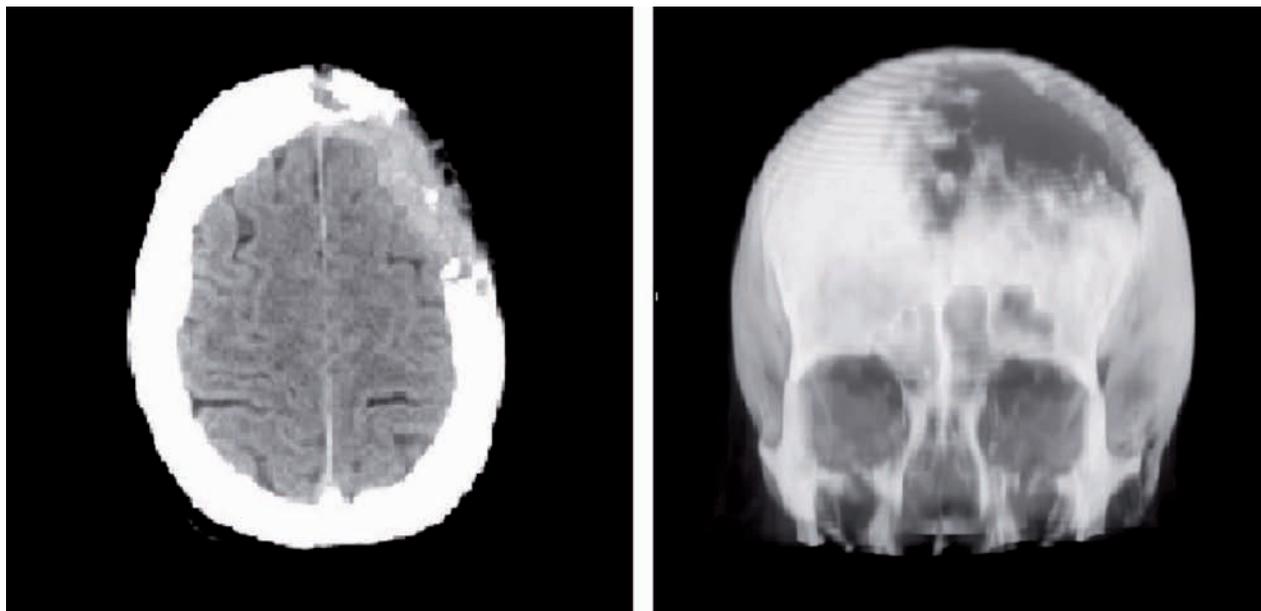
Computed Tomography revealing wide fronto-parietal area of osteolysis
